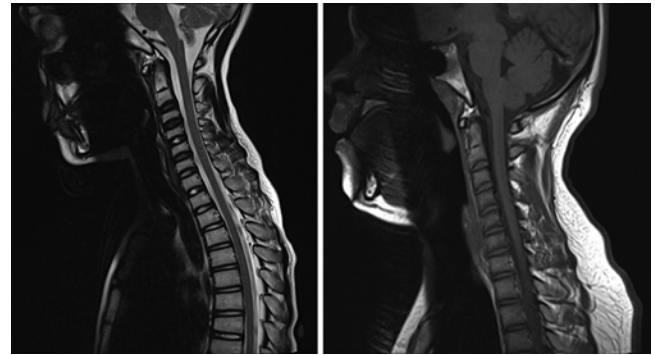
SRC patients with coexisting SCIWORA and central cord neurapraxia. Left: Sagittal T2-weighted MR image obtained in a 13-year-old presenting with hockey-related concussion and 6-week period of bilateral hand numbness and sensory deficit. The image demonstrates no evidence of SCI, ligamentous injury, or spinal stenosis. This patient was successfully returned to contact sport (hockey) following symptom resolution, normal neurological examination, full and painless range of motion, and evidence of normal findings on flexion-extension radiographs without further injury. Right: Sagittal T2-weighted MR image acquired in a 17-year-old child with SRC and transient upper- and lower-extremity numbness and weakness following a tackle in football. The image demonstrates congenital cervical spinal stenosis (cross-sectional anteroposterior canal diameter at C-3 measuring 12 mm) and loss of cervical lordosis. This patient with coexisting central cord neurapraxia and spinal stenosis was advised to retire from contact and collision sports due to elevated risk of future SCI.
